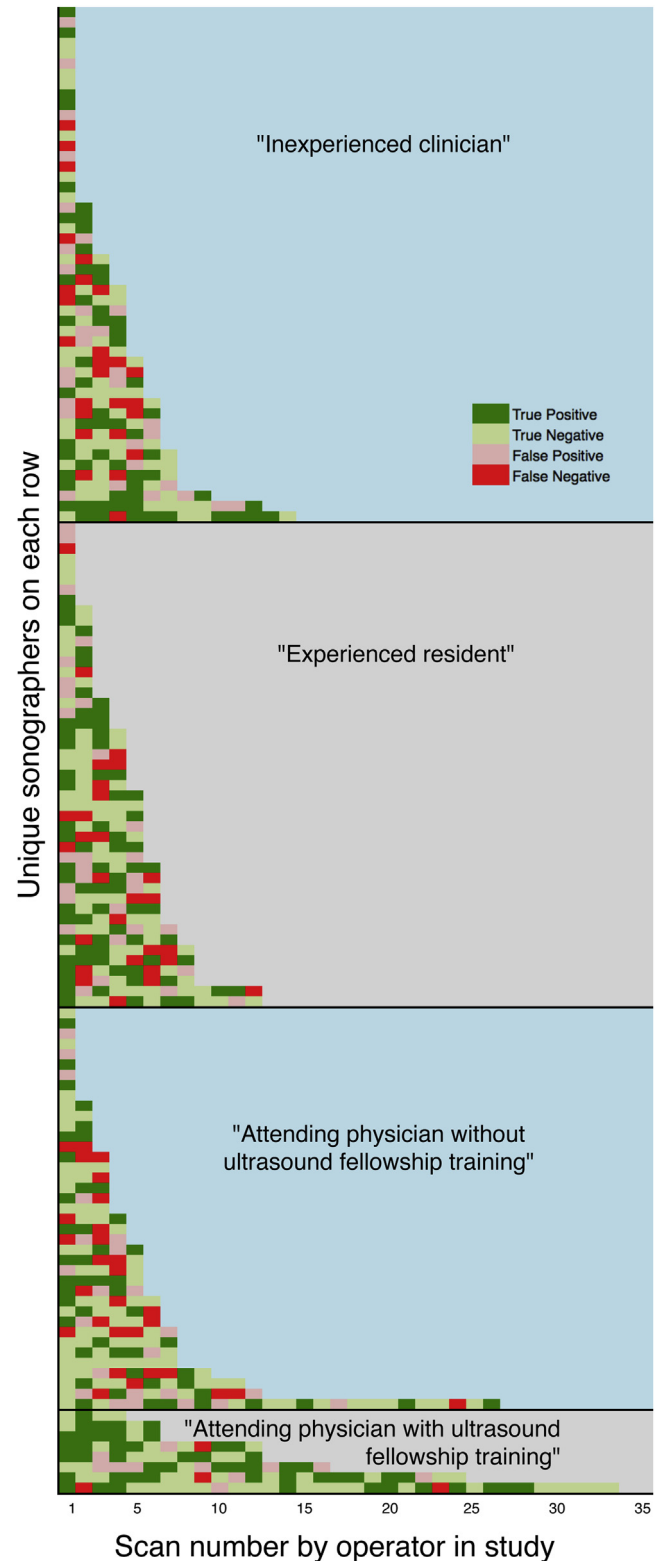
Results of each ultrasonographic test performed (presence of any hydronephrosis on ultrasonography compared with any hydronephrosis on CT), shown with each sonographer representing a row, stratified by group. For this figure, sonographers were placed in the group in which they started the study (because a small number moved to different groups during the study).
